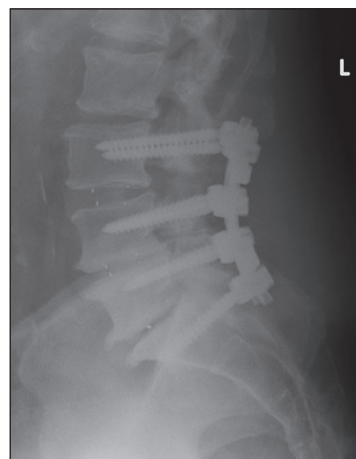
Lateral postoperative X-ray demonstrates typical surgical construct and alignment
